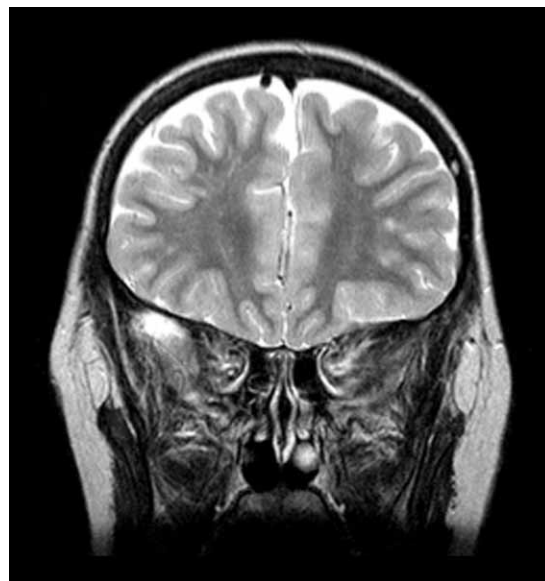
T2 – weighted brain magnetic resonance imaging (MRI) coronal section (repetition time (TR), 5800.0 / echo time (TE), 90.0 ms). Hyperintensity of the white matter in left frontal region.
